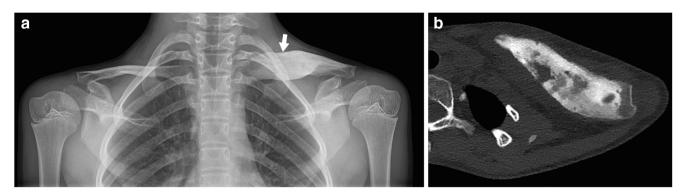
Chronic recurrent multifocal osteomyelitis in a 15-year-old girl with left shoulder pain. a Posteroanterior radiograph of the upper chest shows enlargement and sclerosis of the medial aspect of the left clavicle
